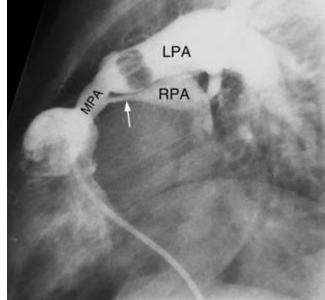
Postoperative stenosis of the right ventricle-to-pulmonary artery conduit and pulmonary arteries. A. Contrast-enhanced MR angiogram shows narrowing of the conduit (C) and main pulmonary artery (MPA). Right (RPA) and left (LPA) pulmonary arteries also show mild stenosis. B. X-ray angiogram from a different patient shows severe narrowing (arrow) of the proximal part of the right pulmonary artery. The main pulmonary artery is also narrow.
